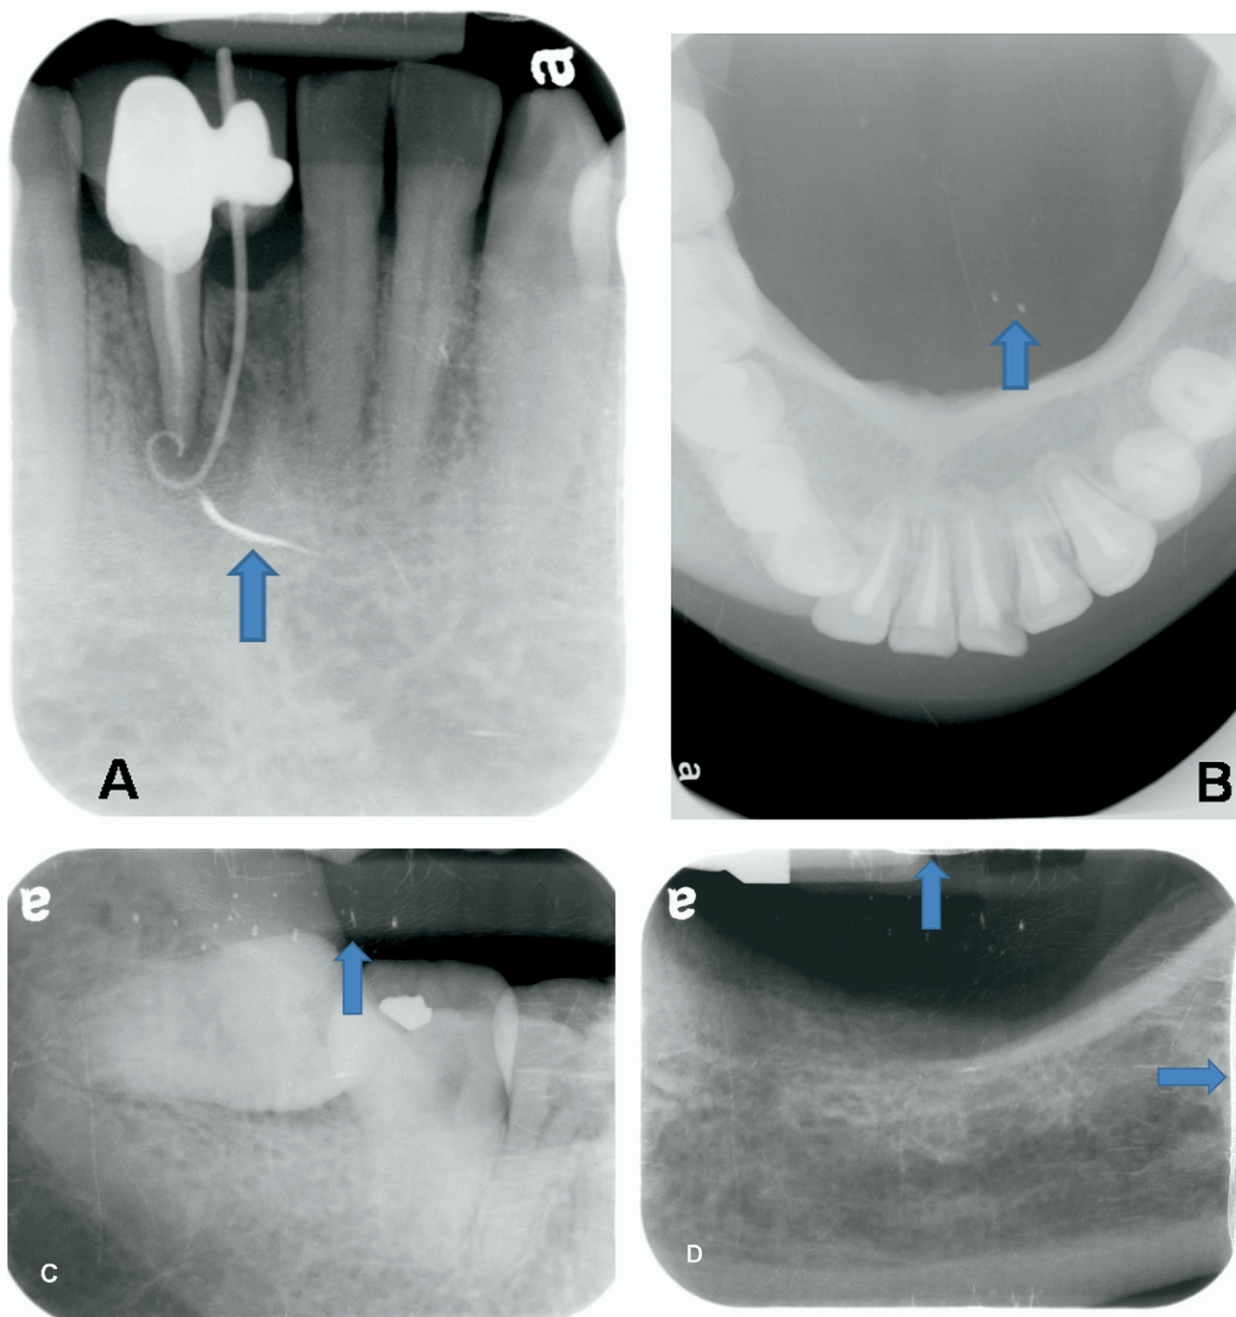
A, A periapical image resulting from a scratched sensor plate, as indicated by the arrow. B, A defective occlusal image due to a tooth mark, as shown by the arrow. C, A defective image resulting from a sensor plate damaged by the teeth of the jaws of a Snap-A-Ray holder, as indicated by the arrow. D, A defective image resulting from the partial peeling of the coating of an intraoral sensor plate, indicated by the arrows.
